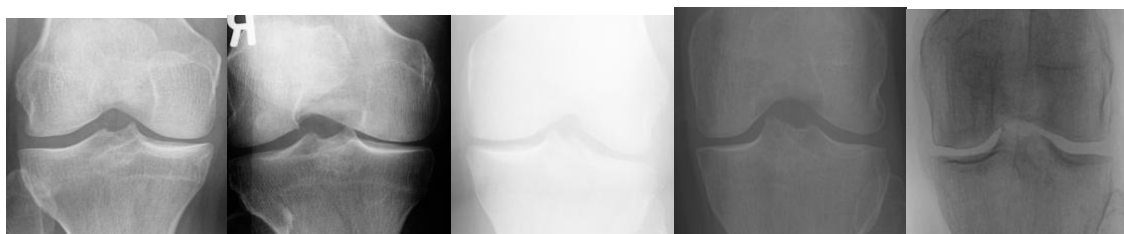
Representative Knee X-ray Images Classified as Grade 1 (Doubtful OA)
